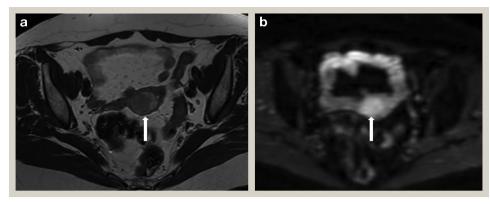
(a) Axial T2W magnetic resonance image demonstrating an intermediate signal intensity mass within the endometrial cavity (white arrow). (b) Corresponding axial DWI image demonstrating high signal intensity representing restricted diffusion within the endometrial cancer (white arrow).
